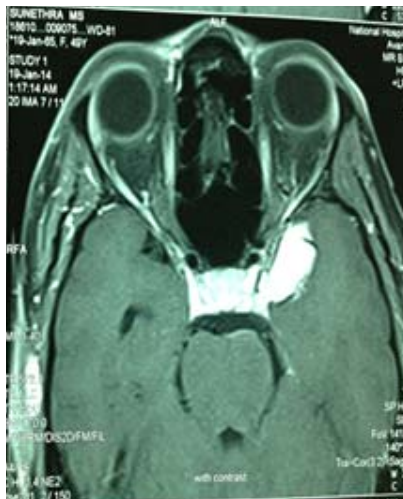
MRI brain showing left lesser wing sphenoid meningioma.
